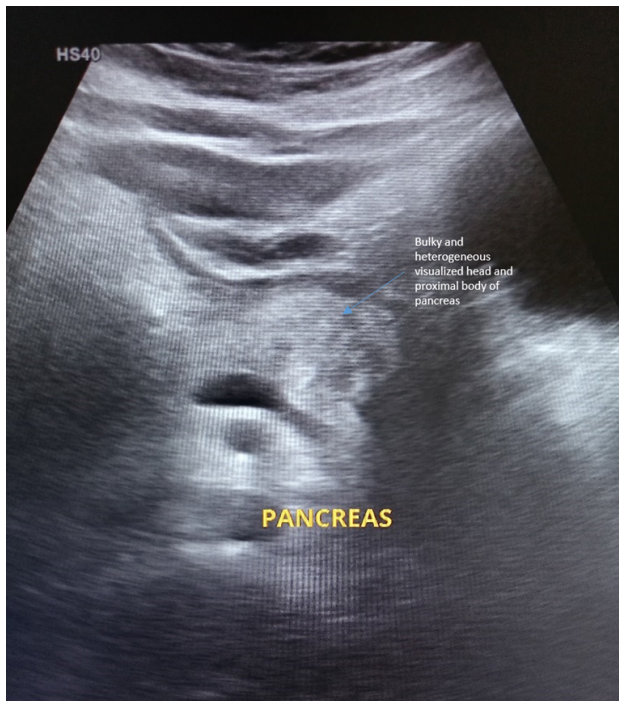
Ultrasound shows Bulky and heterogeneous visualized head and proximal body of the pancreas.
